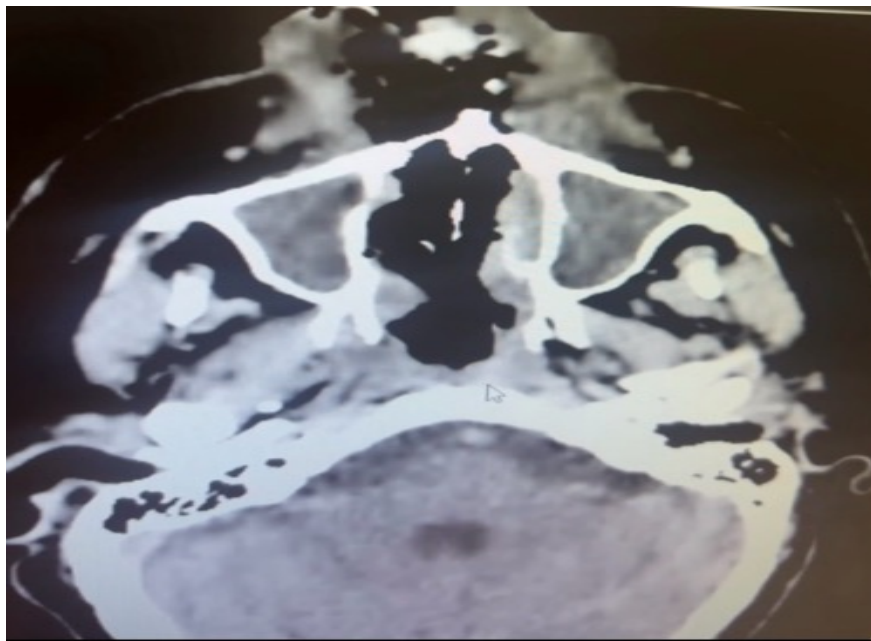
Axial computed tomography (CT) of the paranasal sinuses demonstrating destructive naso-sinus involvement.
